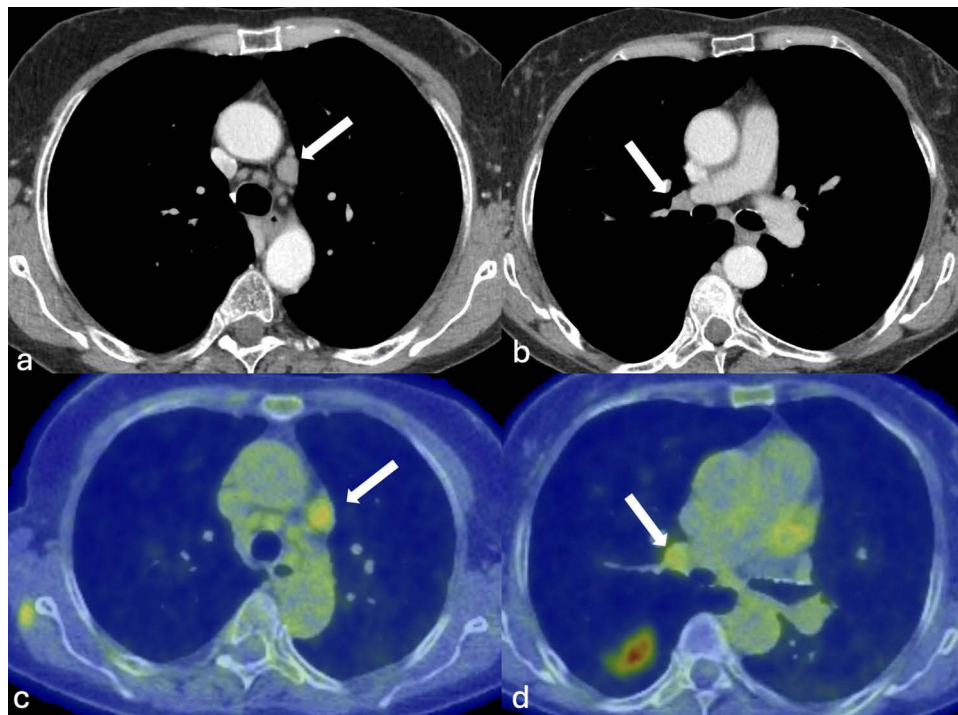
Chest CT showing enlarged metabolically active subaortic (a and c) and right hilar (b and d) lymph nodes (white arrows).
